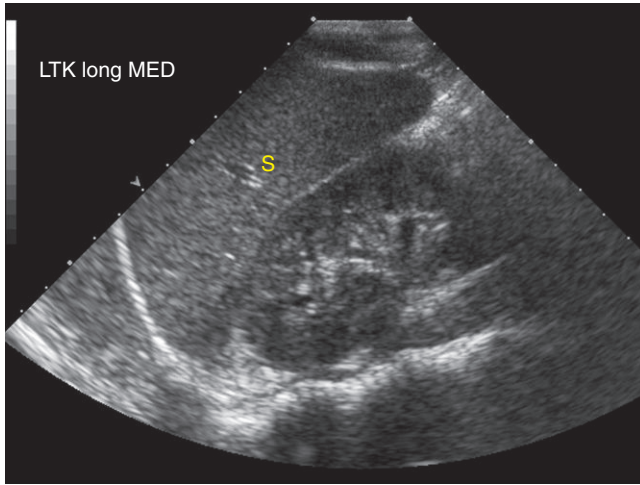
Three-month follow-up ultrasound after therapy demonstrates a more normal appearance to the left kidney. (S=Spleen.)
